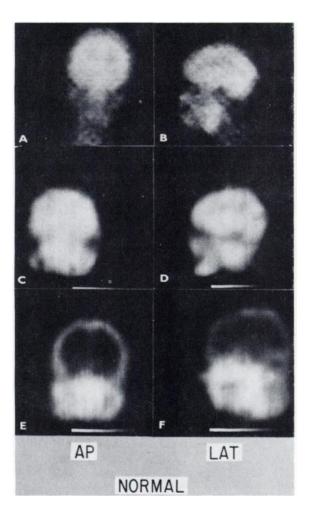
Normal positron scintigrams taken with (A,B) $^{15}NH_{11}$ (linear scanning motion not applied), (C,D) $^{15}O_2$, and (E,F) ^{69}Ga -ATP.
